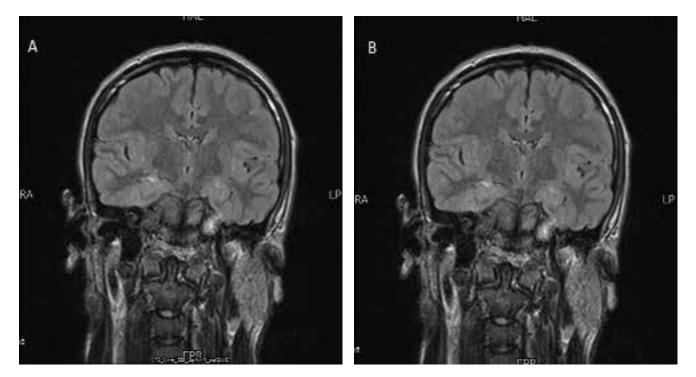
Coronal FLAIR (FIG. A) and post-contrast (FIG. B) showed gyral thickening in the bilateral frontal lobes without abnormal post contrast enhancement.
